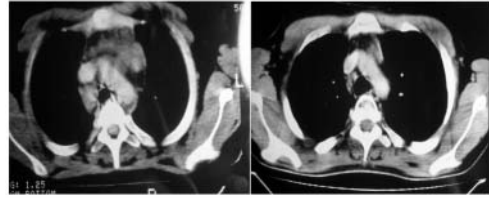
Computed tomography scan of the thorax of a patient before (left) and after (right) thoracic stopflow perfusion.
